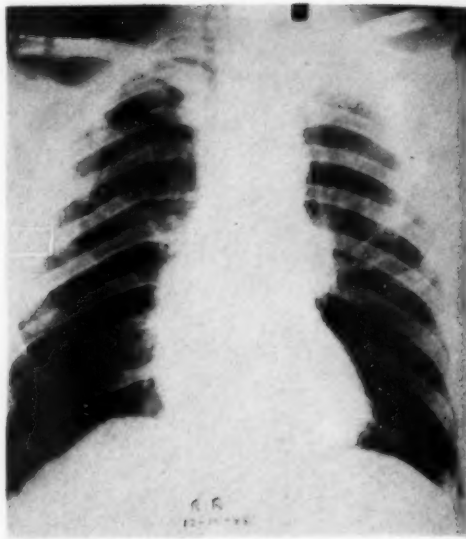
Case 3. Roentgenogram showing glandular mass in the left hilus and soft-tissue mass in the left neck displacing the trachea to the right. No bone erosion was evident.
